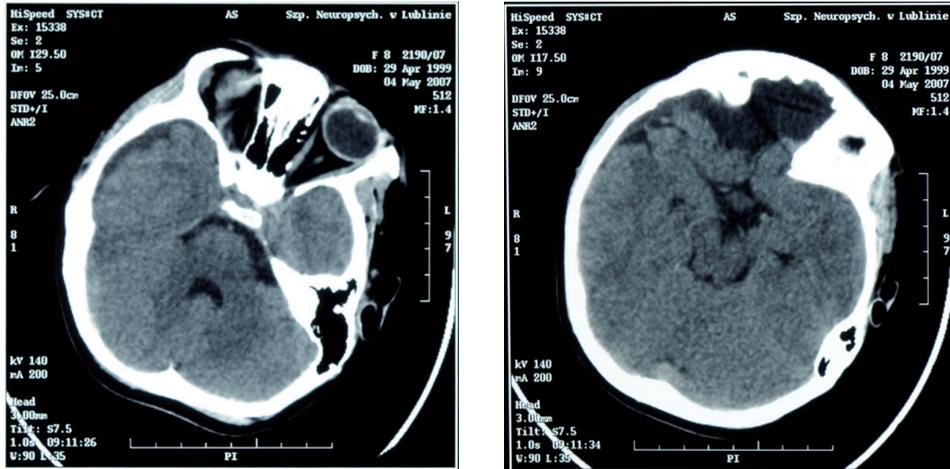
A CT examination of the 8-year-old girl after craniocerebral trauma
